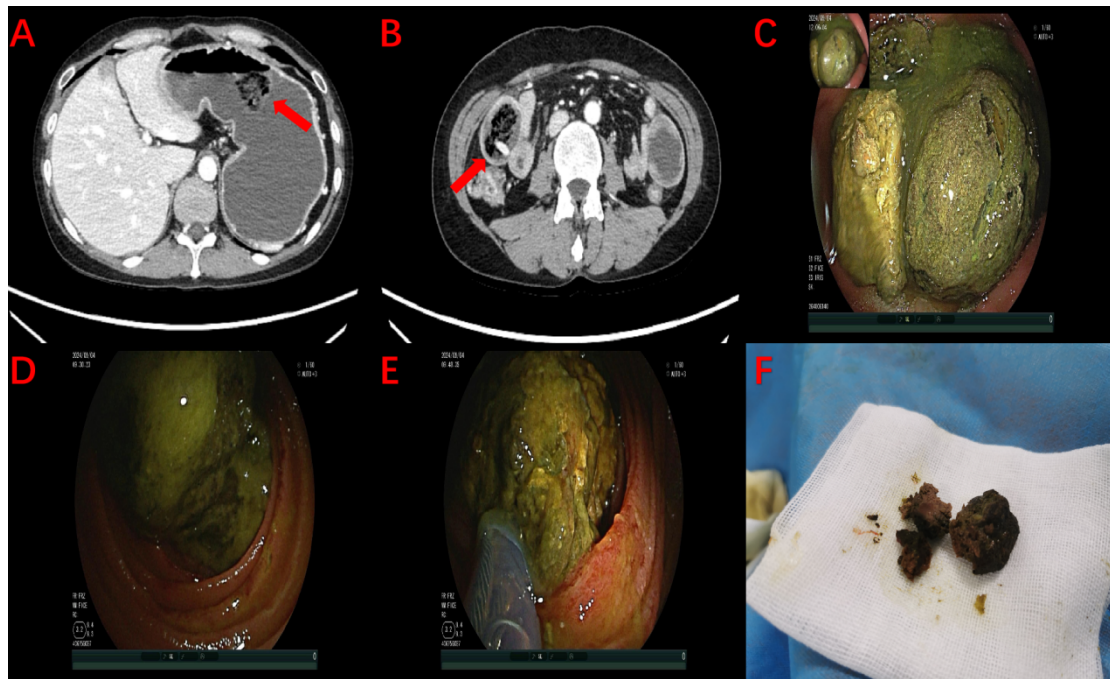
CT scans and enteroscopy of phytobezoar-induced intestinal obstruction. (A) A contrast-enhanced CT scan visualizing the distributions of gas, liquid and phytobezoars. (B) Intestinal dilation and thickening shown on the abdominal CT scan. (C) Gastroscopy visualizing a phytobezoar (5 cm*6 cm) situated in the fundus of the stomach. (D, E) An enteroscope advancing by 100 cm into the pyloric orifice and visualizing a large phytobezoar (5 cm*5 cm) embedded in the jejunum. (F) Removal of phytobezoars by enteroscopic lithotripsy.
